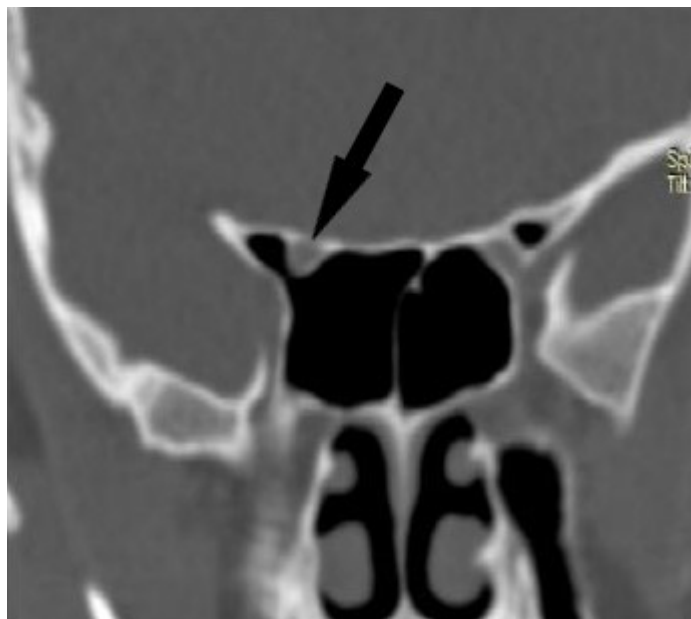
Coronal CT scan, optic canal dehiscence type 3.
